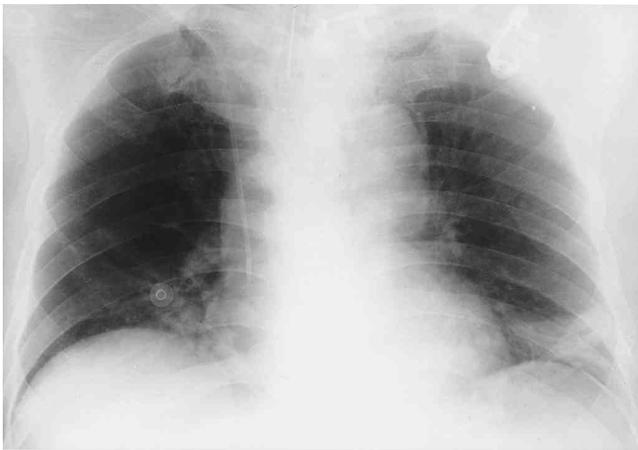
Atelectasis in a 52-year-old man with inhalation burn. Chest radiograph taken ten hours after smoke inhalation shows subsegmental atelectasis in both lower lungs.
